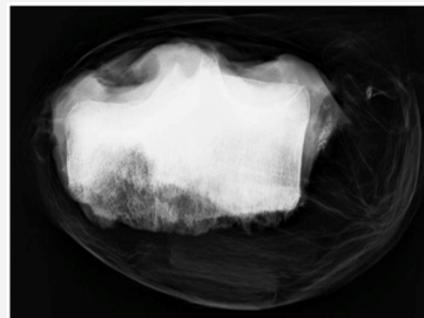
Radiographic image of the tibial plate containing both meniscus, obtained from the corpse.
